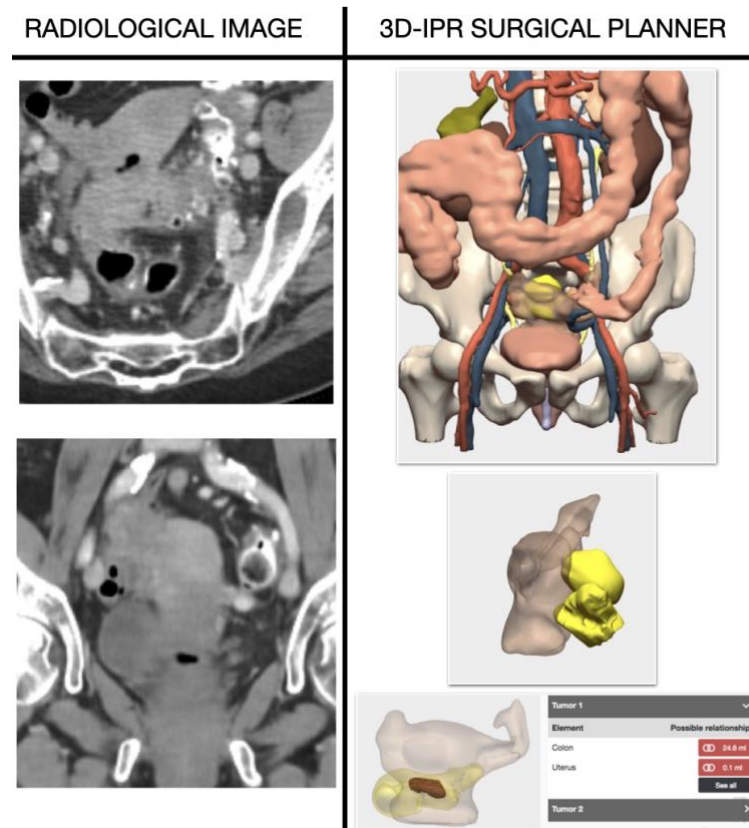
Locally advanced sigmoid colon cancer. CT scan on the left with unclear definition of the plane of separation between tumor, bladder and uterus. 3D-IPR on the right showing uterine infiltration, no bladder intrusion as well as exact tumoral size and location.
